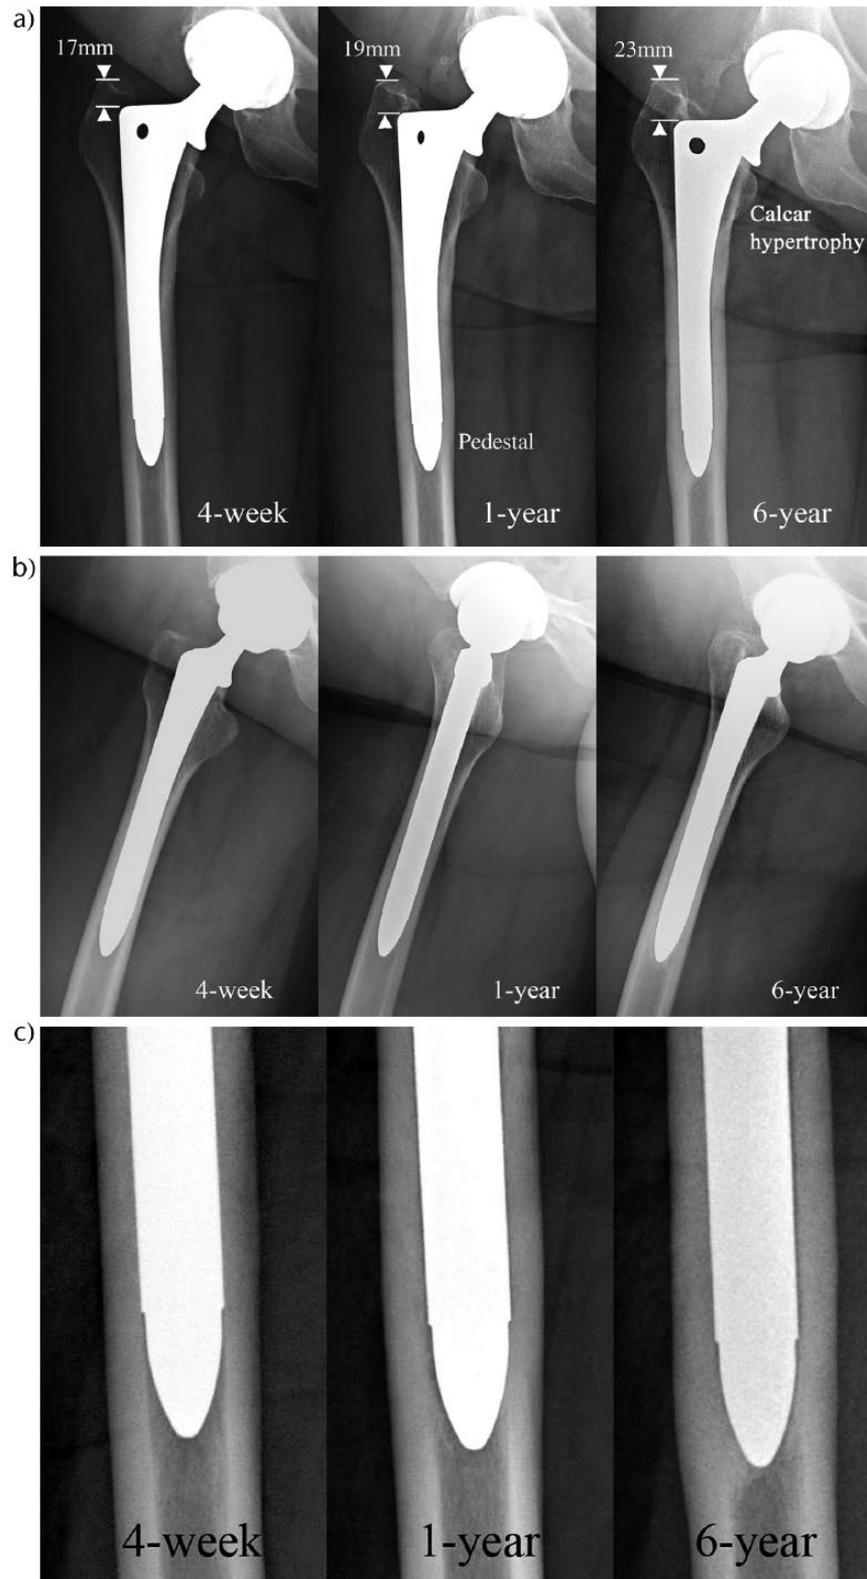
A loose stem characteristic hallmark is distal stem migration. a) Successive AP radiographs of an AML® stem at four weeks, one year and six years post-operatively showing an increase in the distance between the tip of the femoral stem and the tip of the greater trochanter, indicating distal stem migration. Pedestal formation can be seen as early as one year post-operatively. b) Lateral views showing the pedestal formation. c) A close-up view of the distal stem showing more of these changes.
